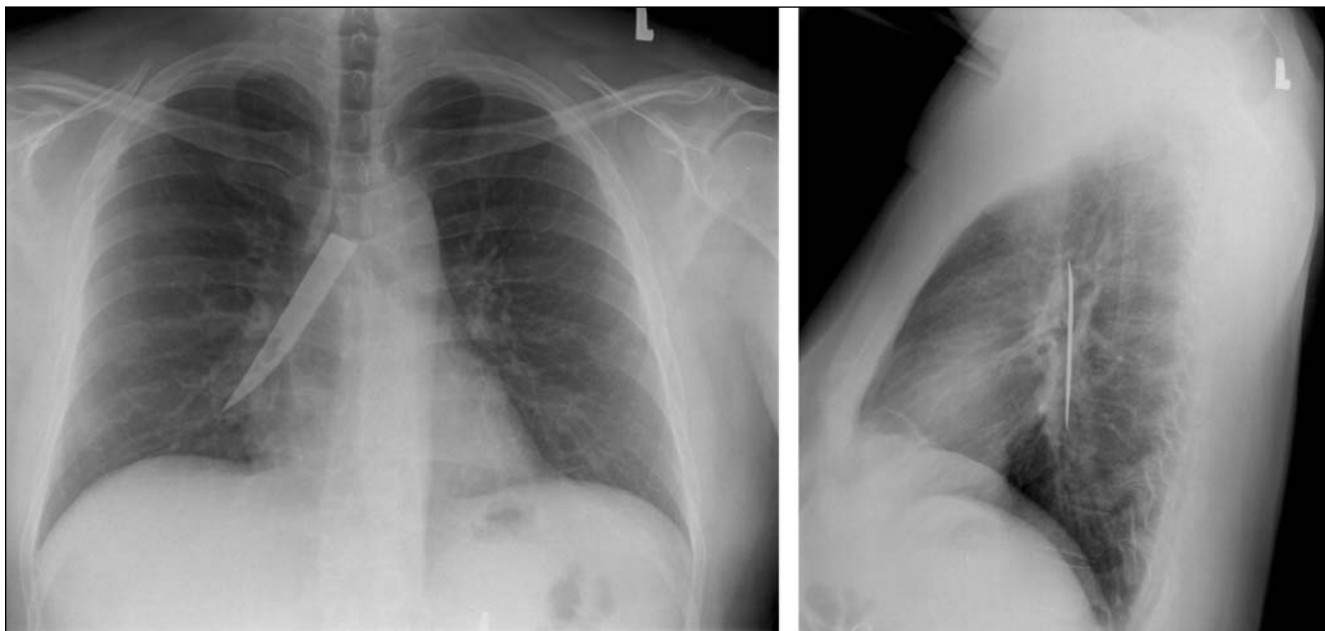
Posteroanterior (left) and lateral (right) chest radiographs showing a metallic object (a steak-knife blade) in the right main-stem bronchus.
